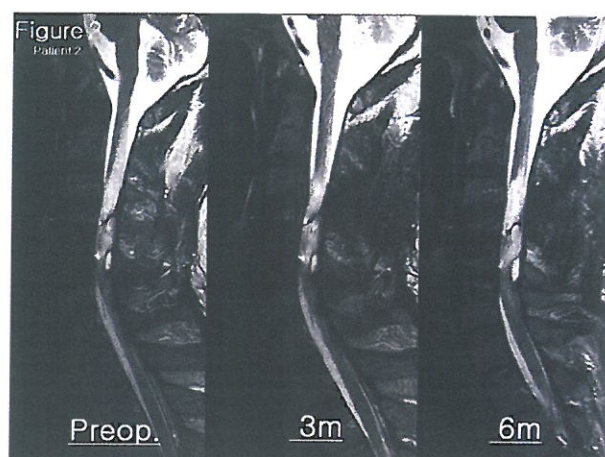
In Patient 2, T2 weighted image of the follow-up MRI showed decrease of high signal intensity in C2 level of spinal cord.
